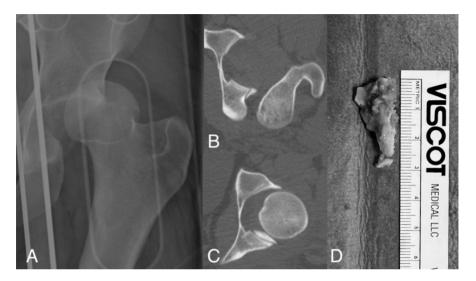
A: Anteroposterior left hip X-ray showing a posterior dislocation; B: Axial CT-scan view showing the posterior dislocation and a fracture of the posterior wall of the acetabulum; C: Axial post-reduction CT-Scan view showing a retained intraarticular fragment of the posterior wall fracture; D: Intraoperative view of the removed fragment of the posterior wall.
